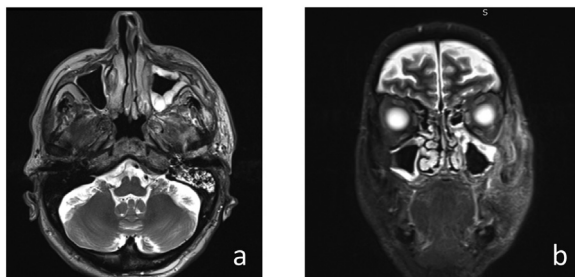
(A, B) MRI shows on the left side, inhomogeneous perimaxillary, lateral periorbital, and perizygomatic soft tissue signal and the presence of phlogistic tissue affecting the parietal profiles of the maxillary sinus.
